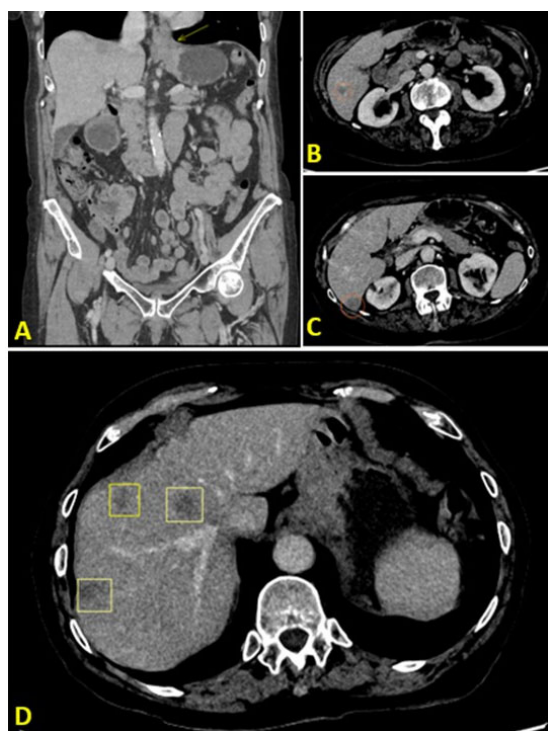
CT March 2023 showing stable gastro-esophageal junction mass (A), hepatic metastases (B, C), and newly developed hepatic metastases (D) suggesting disease progression despite on first-line palliative chemotherapy with oral capecitabine and intravenous oxaliplatin (CAPOX).
